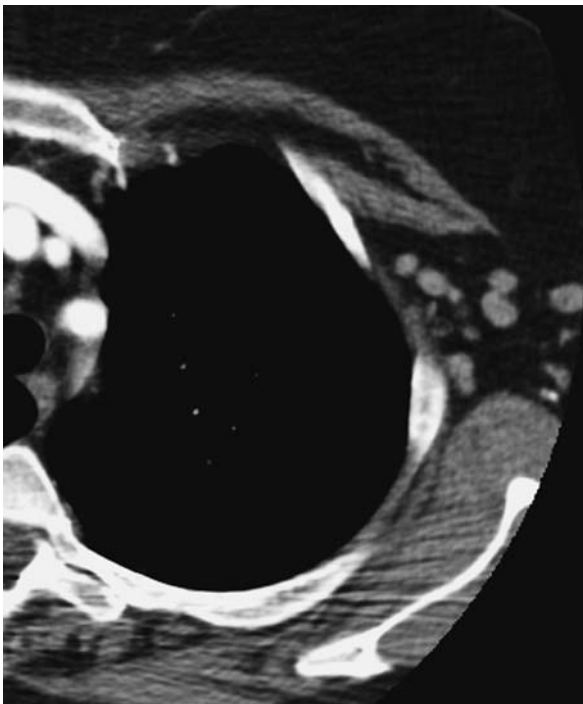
CT shows large axillary lymph nodes (a) and focal pulmonary consolidation (b) in a patient with lymphoproliferative disease
